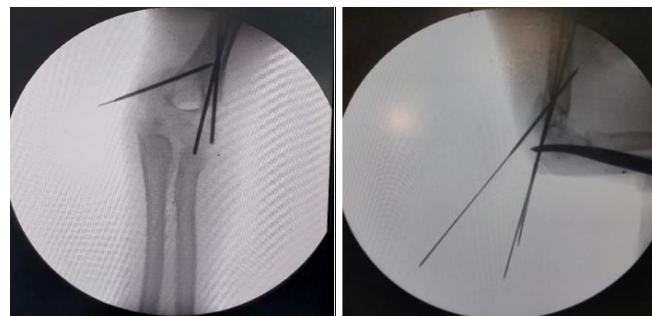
Intraoperative X-ray imaging of elbow
